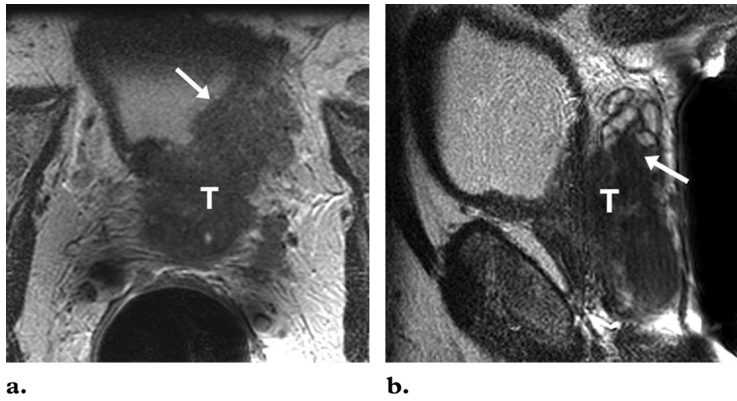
Biopsy-proved Gleason grade 8 adenocarcinoma in a 58-year-old man with a PSA level of 50.0 ng/mL. T2-weighted axial (a) and sagittal (b) MR images reveal a large tumor (T) that invades the entire prostate gland and demonstrate gross extracapsular extension and direct invasion of the urinary bladder (arrow in a) and seminal vesicles (arrow in b).
